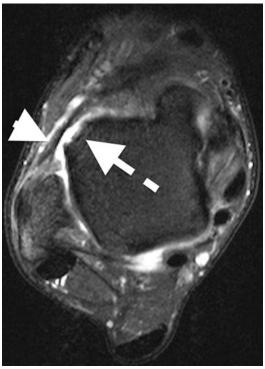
Axial T2FS MRI of the ankle with osseous avulsion (*dashed arrow*), anterior talofibular ligament at fibular attachment, ligament is thickened, intermediate signal (*arrowhead*) with surrounding edema and small joint effusion
